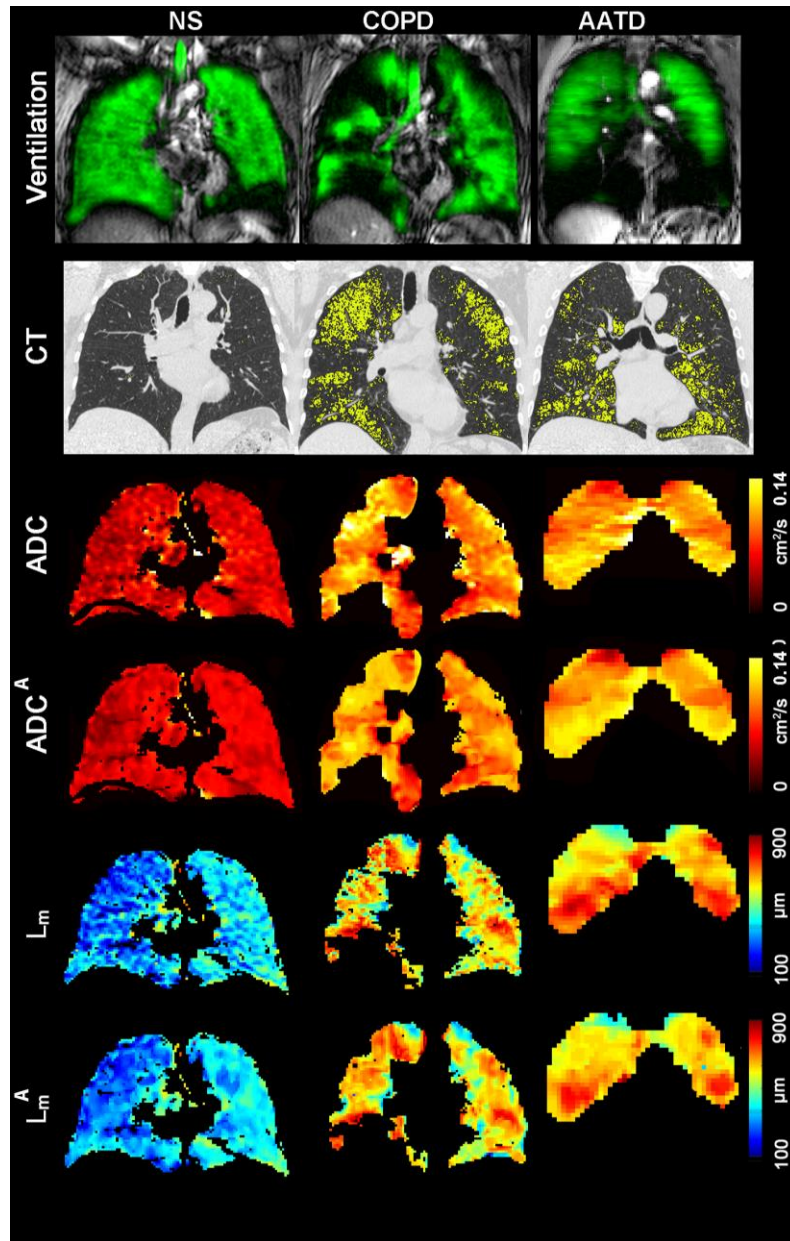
Representative CT and ^{129}Xe MRI Maps
